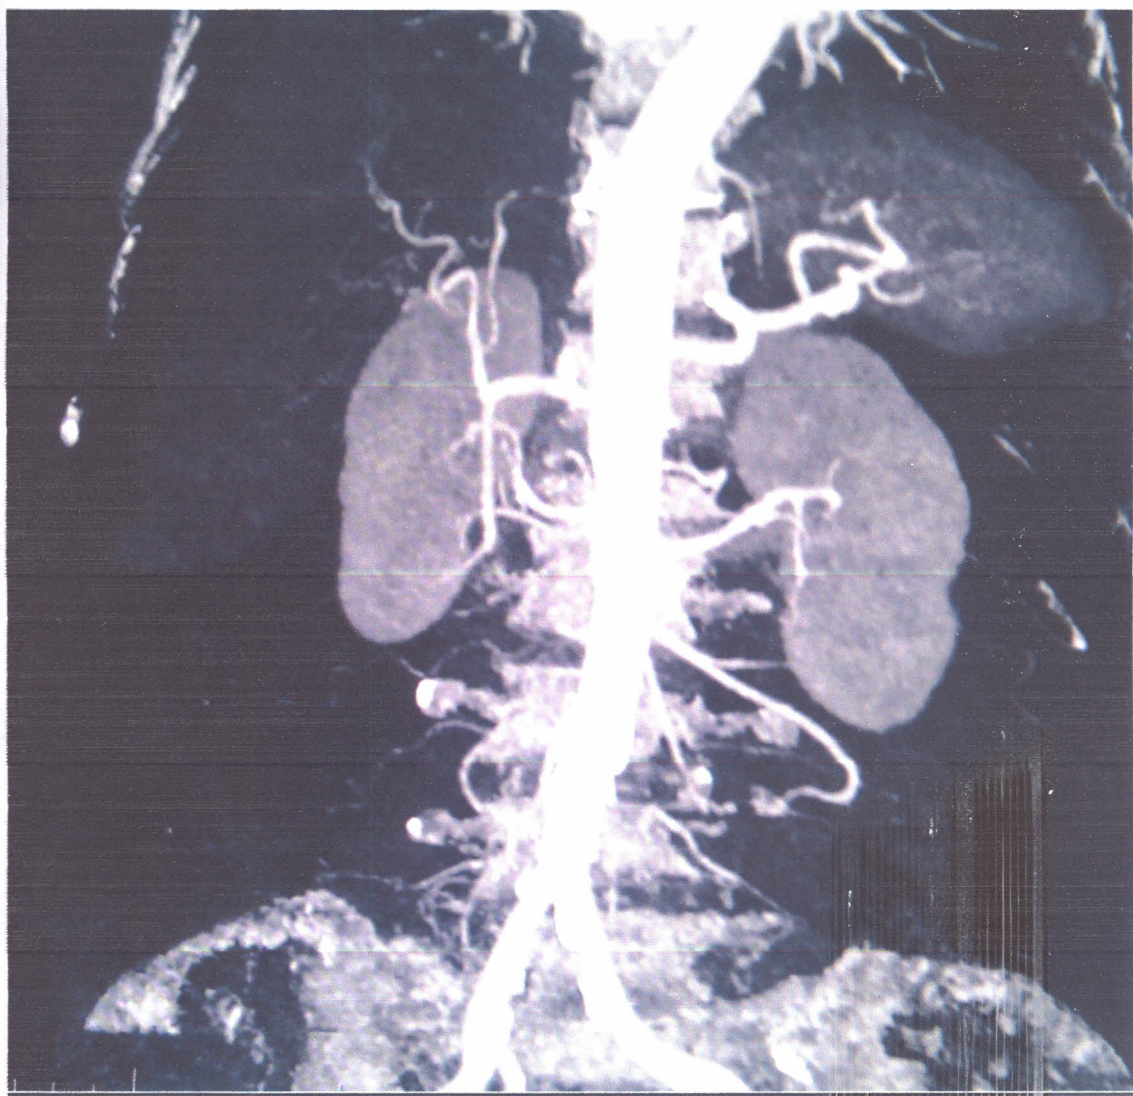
MIP Renal CTA of an adult 47years female potential donor small right accessory renal artery.
